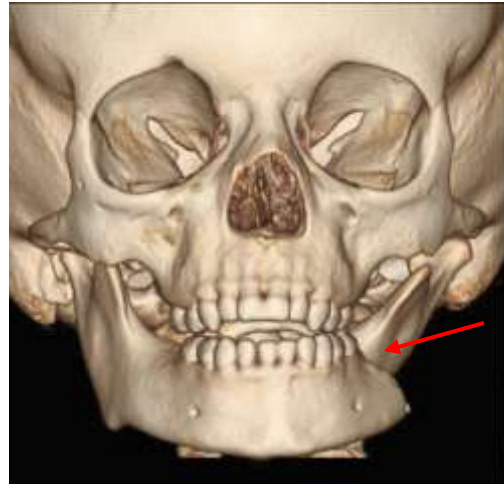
CT scan of a displaced fracture of the right condylar neck in a 3-year-old (Lim and Hopper, 2021).
